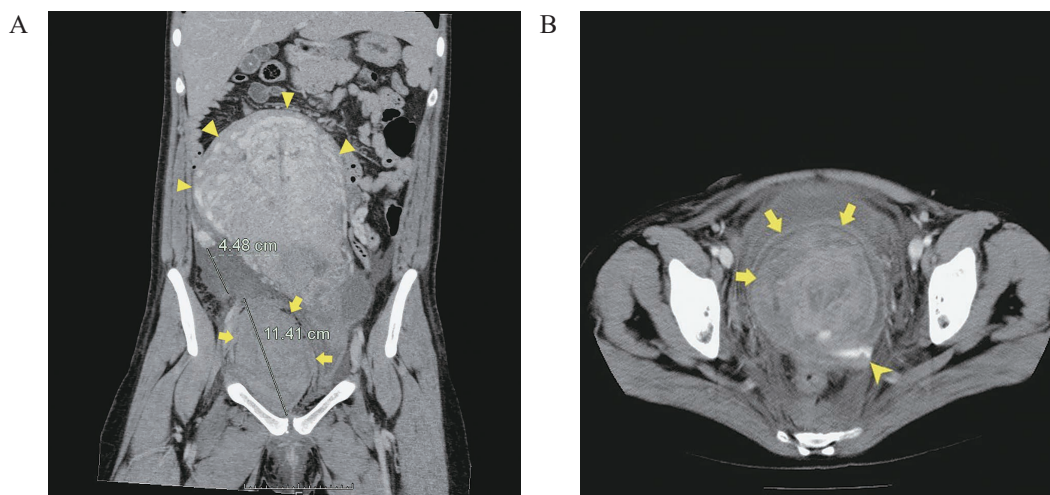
Representative contrast-enhanced CT images of PGHA with and without extravasation.
